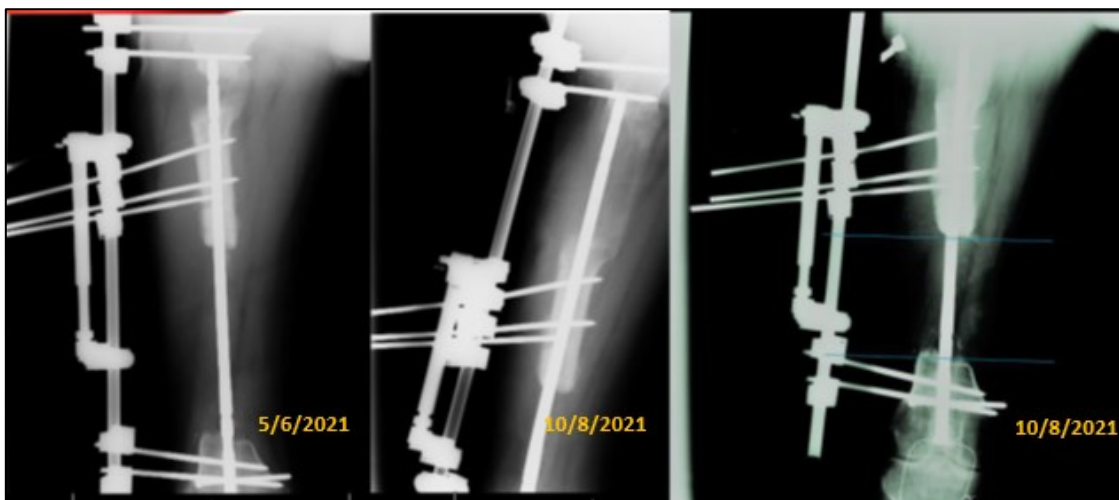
Follow-up X-rays at 2 and 4 Months Post-Second Surgery
